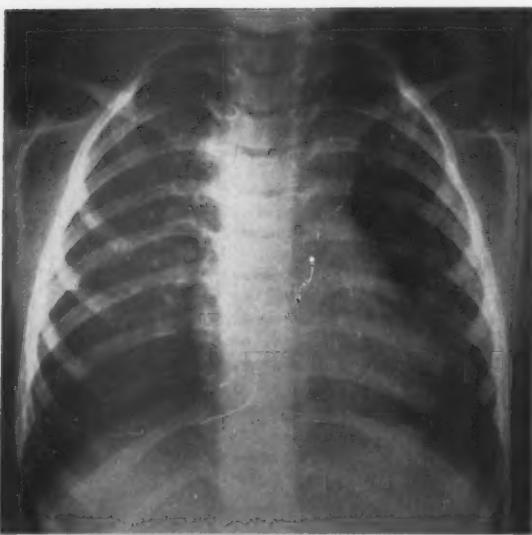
Standard roentgenogram of the chest in the posteroanterior view, showing the large vascular pedicle.
